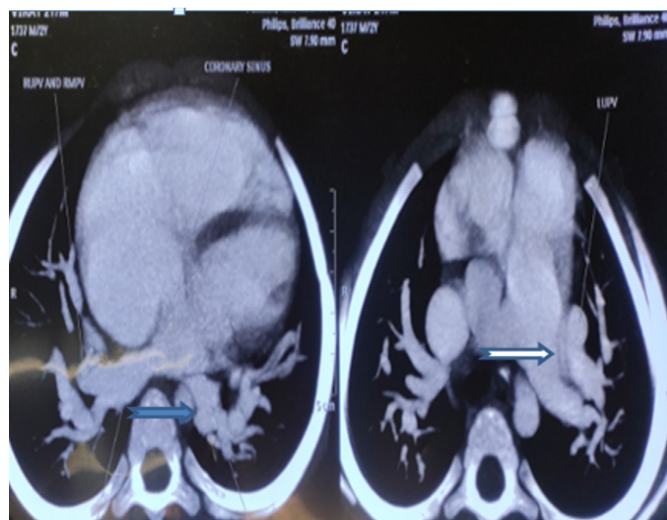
Computed tomography (CT) scan of the patient wherein, the blue arrow indicates drainage of left lower pulmonary venous drainage into cardiac chamber and vertical vein and white arrow indicates formation of vertical vein from left upper and branch of left lower pulmonary vein.
